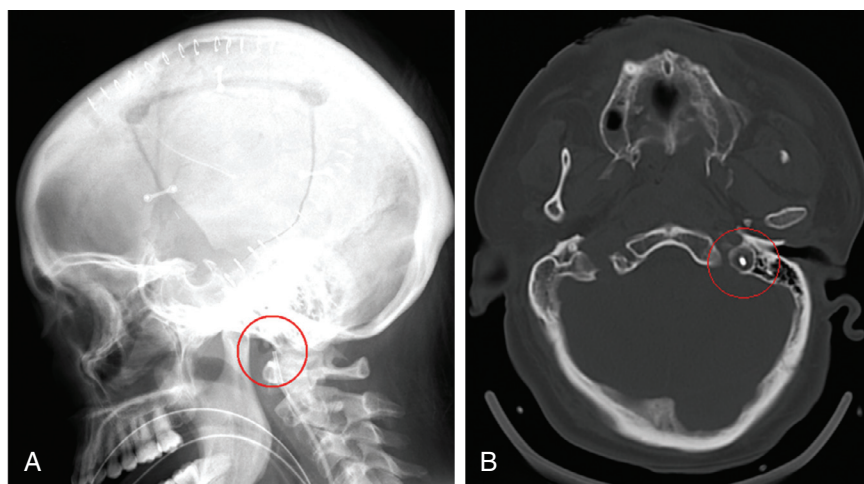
■ A, Lateral skull x-ray confirming adequate SjvO₂ catheter placement at the C1-C2 level. B, Head computed tomography scan showing the catheter tip correctly placed at the jugular venous bulb level.
